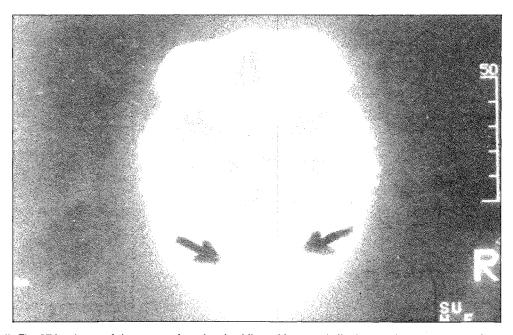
The CT head scan of the same patient showing bilateral intracerebellar haemorrhage; more extensive on the right side (indicated by arrows).
